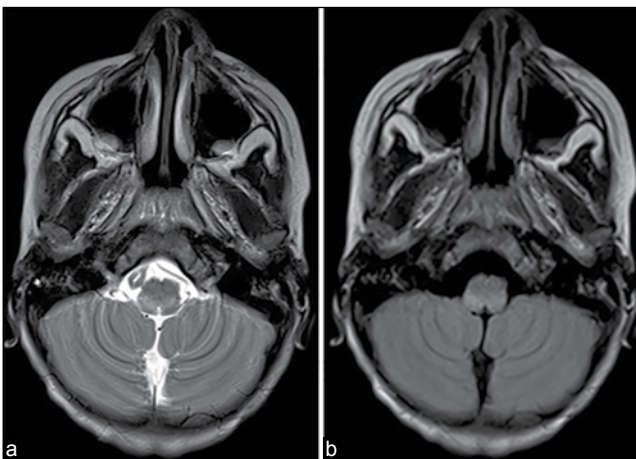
Axial T2/FLAIR MRI images reveal hyperintense lesions involving dorsal medulla
